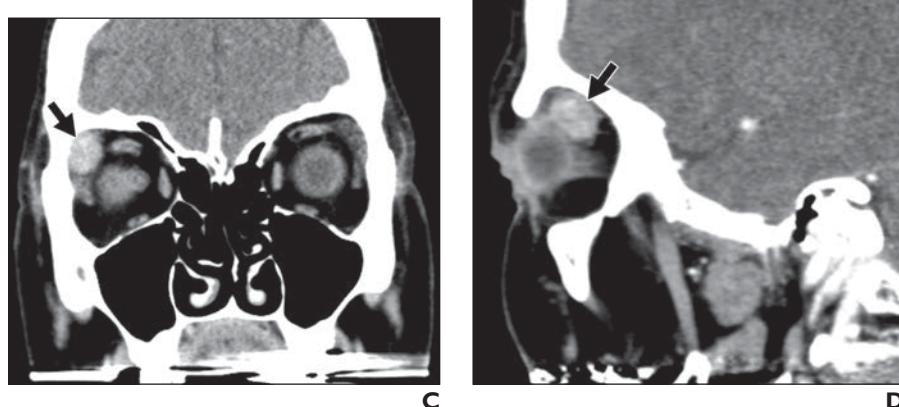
Mucoepidermoid carcinoma. A–D, Contrast-enhanced axial (A), coronal (B), and sagittal (D) CT images show homogeneously enhancing mass in orbital lobe of right lacrimal gland (arrows), with associated subtle bone remodeling (arrowhead, B).
